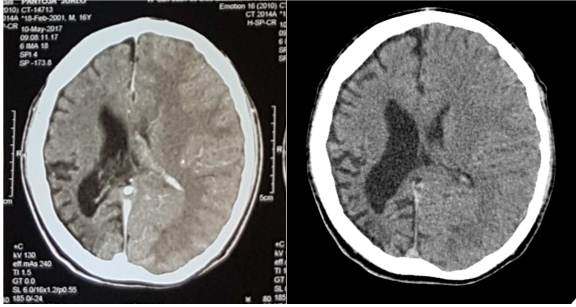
Plain cranial CT scan done in 2017 (above) and 2018 (below) showing right hemisphere atrophy, right frontal sinus hyperpneumatization widening of the right lateral ventricle and compensatory thickening of the calvarium.
